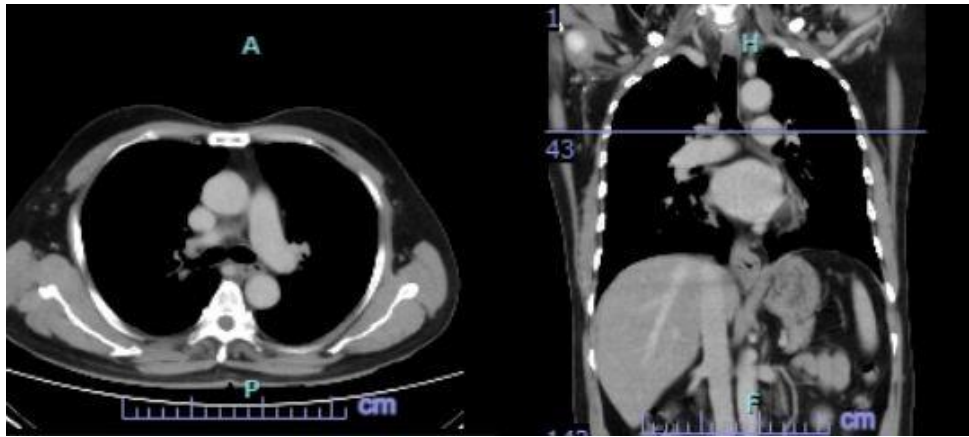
Post-chemotherapy CT scan showing stable disease according to RECIST criteria.
